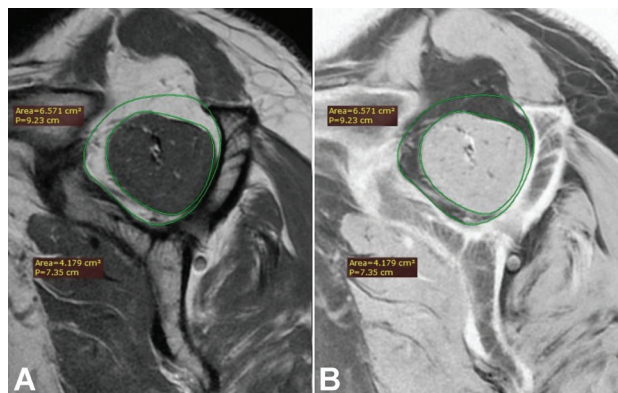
Sagittal oblique T1-weighted magnetic resonance imaging scans at the level of the scapular-Y view. Calculation of the occupation ratio using (A) the *closed polygon* tool and (B) the *negative* tool in the RadiAnt Digital Imaging and Communications in Medicine viewer to confirm the slice showing the bony landmark.
